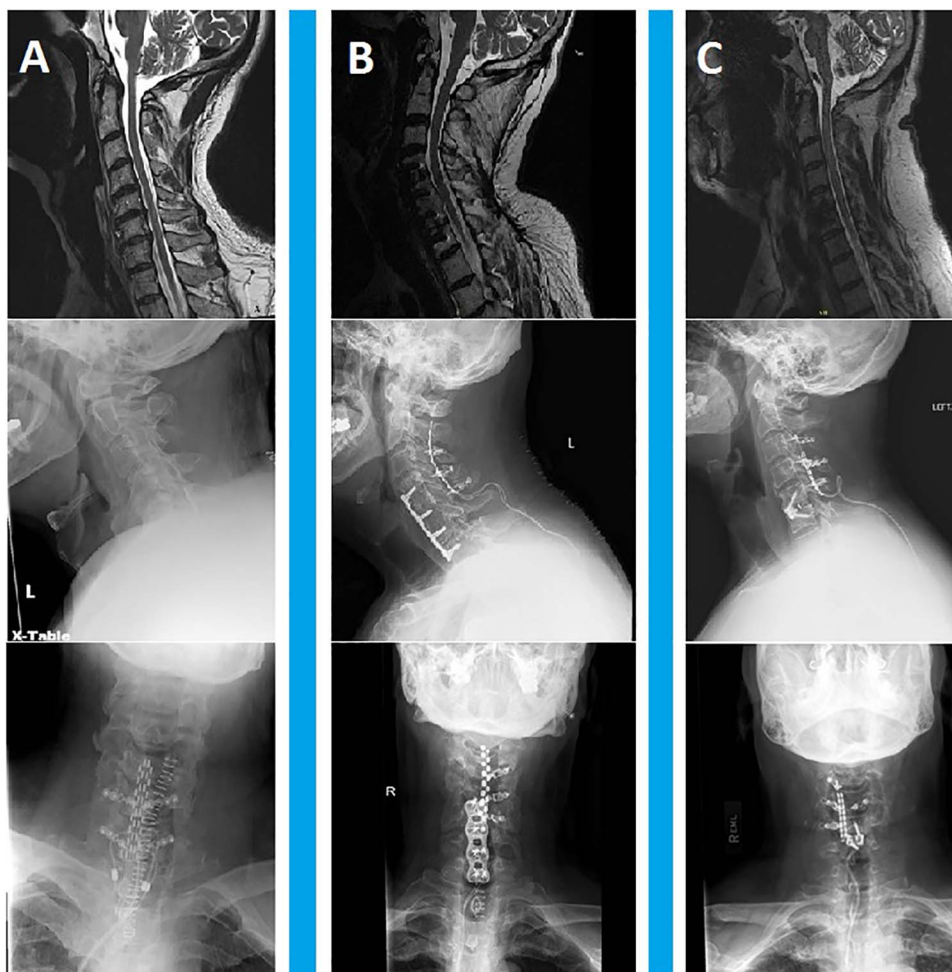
Preoperative and postoperative imaging of the 3 cases. A. Imaging of patient 1. Preoperative (top image) sagittal T2-weighted magnetic resonance imaging (MRI) shows cervical stenosis, and early postoperative (middle image) anteroposterior and (bottom image) lateral x-rays show the instrumentation of laminoplasty and good placement of the paddle lead. B. Imaging of patient 2. Preoperative (top image) sagittal T2-weighted MRI shows good alignment of the spine and previous anterior fusion from C4-C7, and early postoperative (middle image) anteroposterior and (bottom image) lateral x-rays show the instrumentation of laminoplasty and good placement of the paddle lead. C. Imaging of patient 3. Preoperative (top image) sagittal T2-weighted MRI shows good alignment of the spine and previous anterior fusion at C5-C6, and early postoperative (middle image) anteroposterior and (bottom image) lateral x-rays show the instrumentation of laminoplasty and good placement of the paddle lead.
